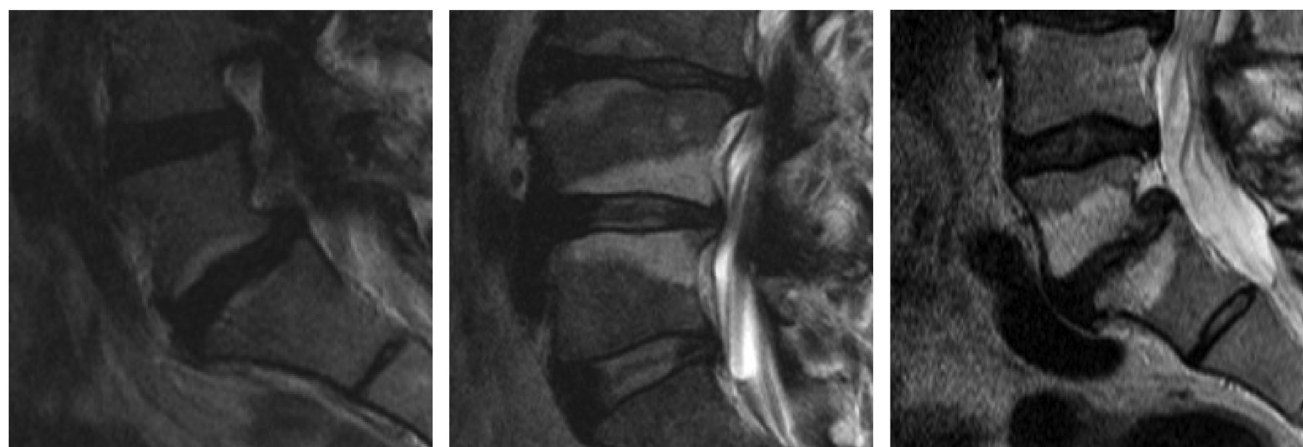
MC grade 1 (less than 25% of the vertebral body), grade 2 (between 25% and 50% of the vertebral body), and grade 3 (more than 50% of the vertebral body) on T2-weighted MRI.
